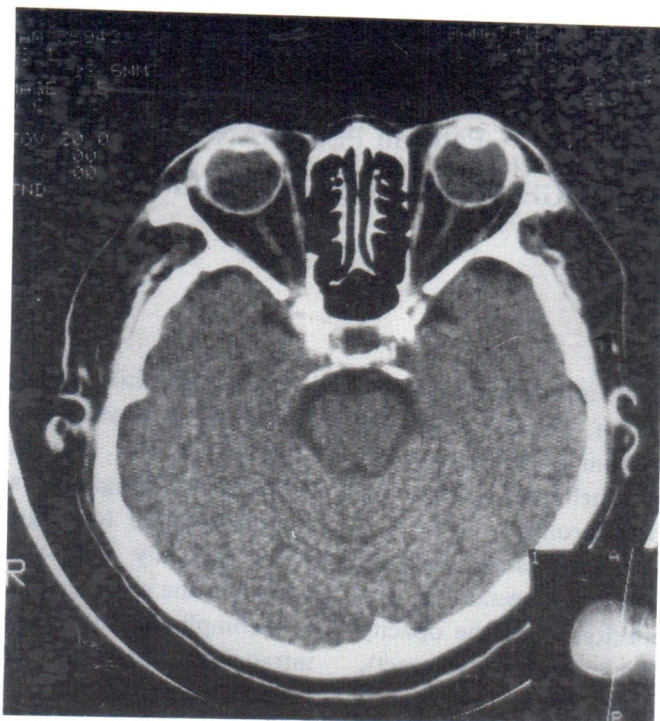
CT scan of the orbits showed flattened opaque artificial lens of right eye.
